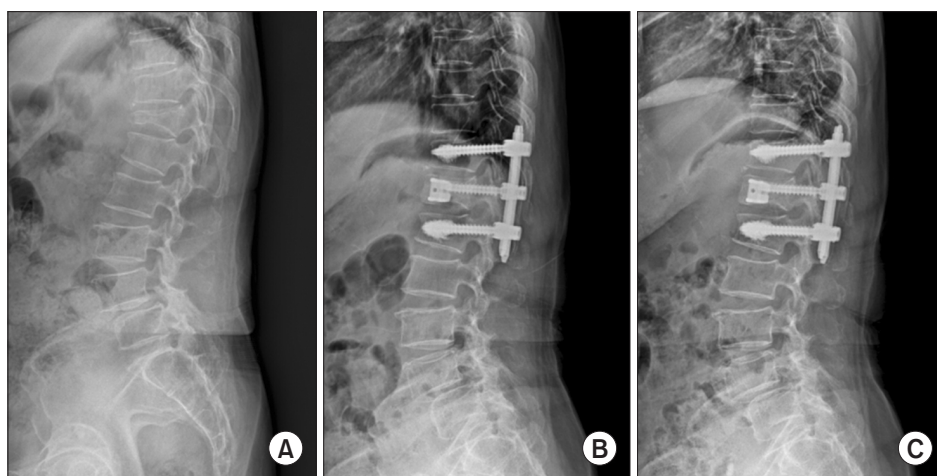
A 72-year-old female patient with thoracolumbar Kummell disease, who underwent percutaneous transpedicular intravertebral cage augmentation and cement-augmented short-segment pedicle screw fixation. (A) Preoperative standing lateral x-ray. (B) Immediate postoperative lateral x-ray showing the restored vertebral height and satisfactory alignment. (C) Follow-up x-ray at 1 year after surgery showing well-maintained alignment.
